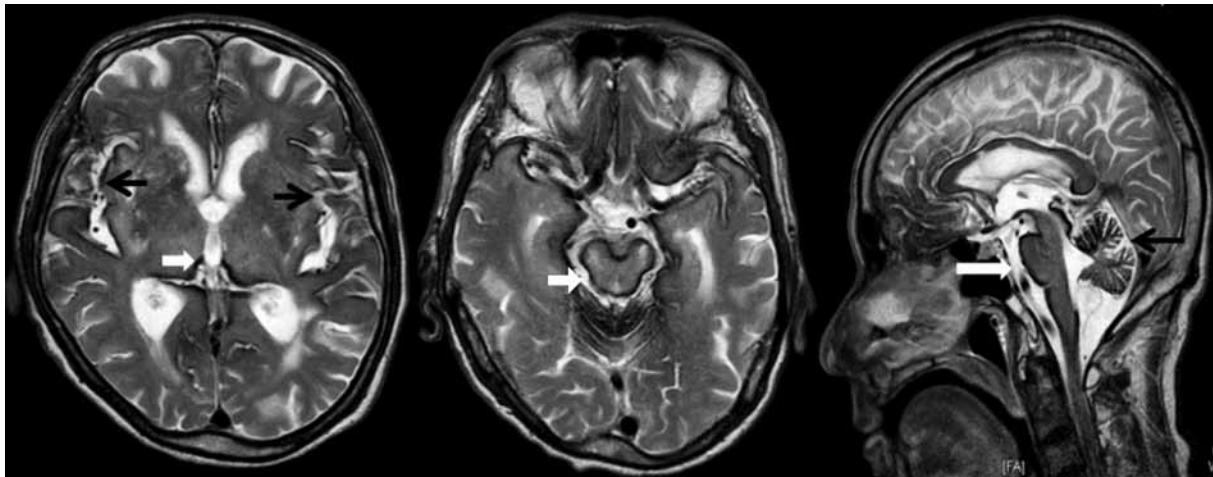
(a and b) Axial T2-weighted MRI slices showing hemosiderin deposition over meningeal surfaces of basal cistern (white arrow), sylvian fissures (black arrows), and around brainstem (white arrow). (c) Sagittal T2-weighted MRI slice showing hemosiderin deposition around brainstem (white arrow) and meningeal surface of brainstem (black arrow).
